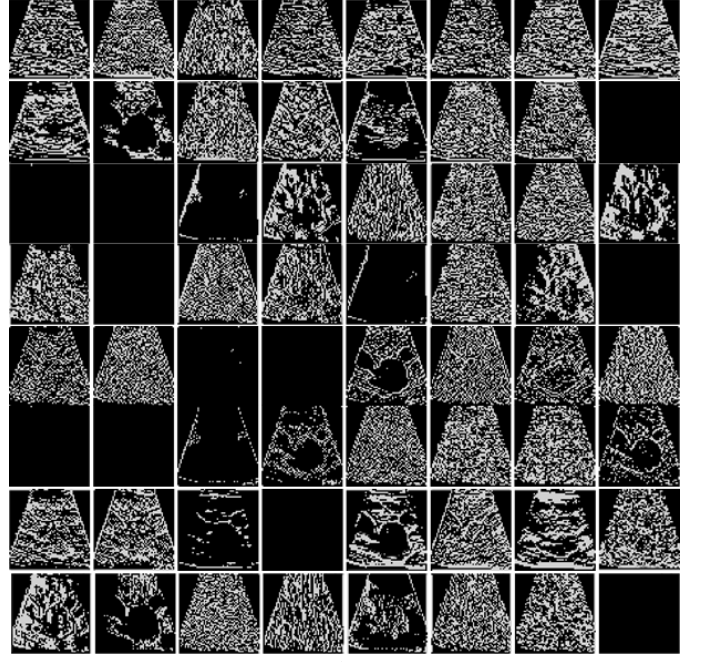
The feature map of a randomly selected ultrasonic image in a dataset after the pooling layer of the original residual network, with the dimension of $64 \times 56 \times 56$.
